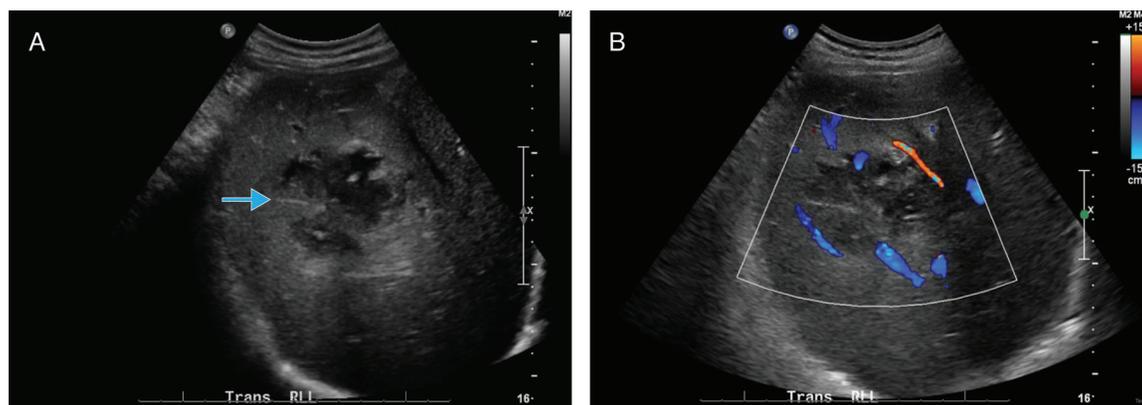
Ultrasound (US). A. US demonstrates a hypoechoic abscess with heterogeneous echogenicity centrally consistent with septations and internal debris (blue arrow). B. Color Doppler US demonstrates peripheral hypervascularity surrounding the abscess cavity.
